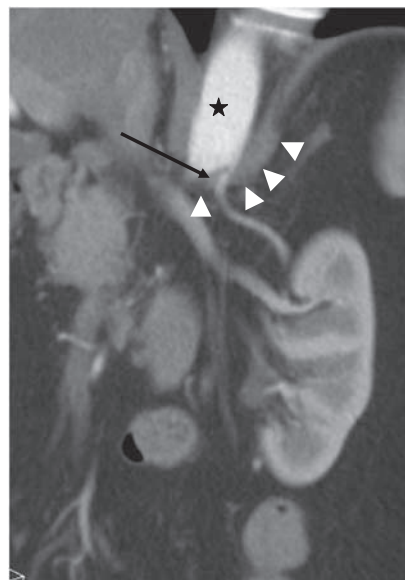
Computed tomography scan: coronal curved multiplanar reconstruction image of the left RA (black arrow), which shows arterial entrapment between the aorta (black star) and the left diaphragmatic crus (white arrowheads).
